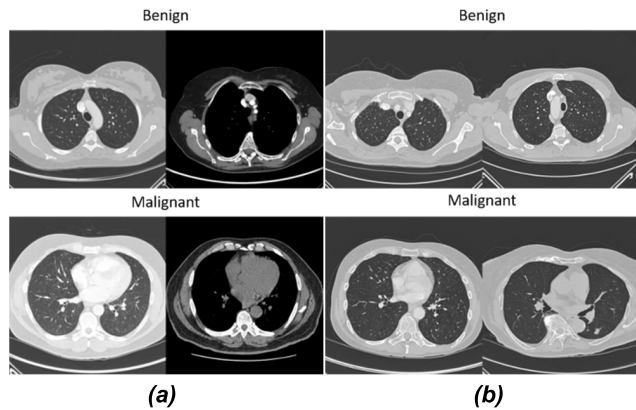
(a) SPIE-AAPM lung CT images. (b) LIDC-IDRI lung CT images.
